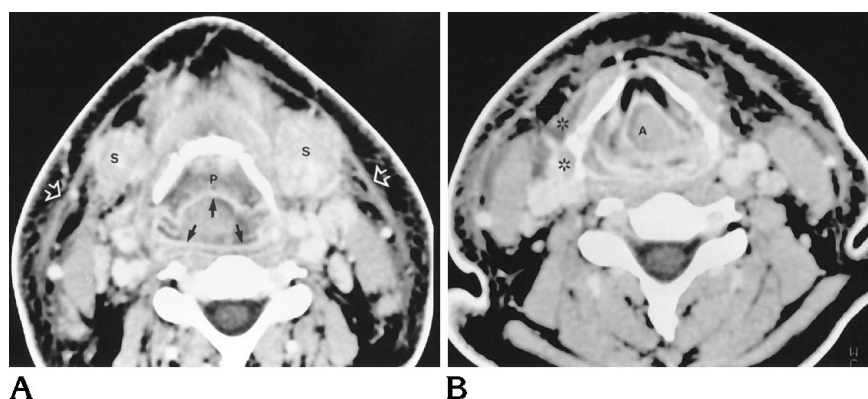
A, Axial postcontrast CT scan shows marked enhancement of the pharyngeal mucosa (black arrows) and submandibular glands (S). There is thickening of the platysma muscle (white arrows) and reticulation of the subcutaneous fat. The preepiglottic fat is obscured by edema (P).
